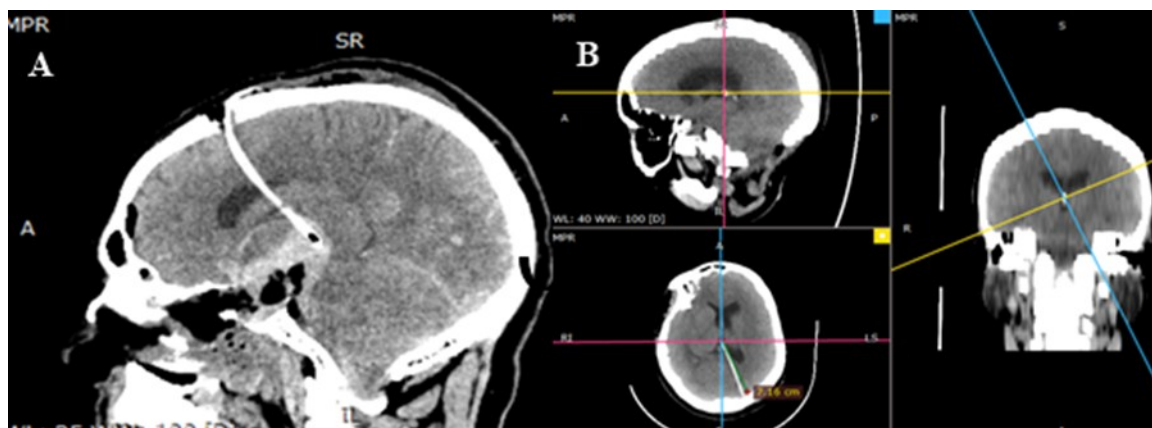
Obliquely reformatted CT scan showing intracranial catheter length measurement: A) Intracranial catheter length measurement for Kocher's EVD. B) Intracranial catheter length measurement for Frazer's EVD.
